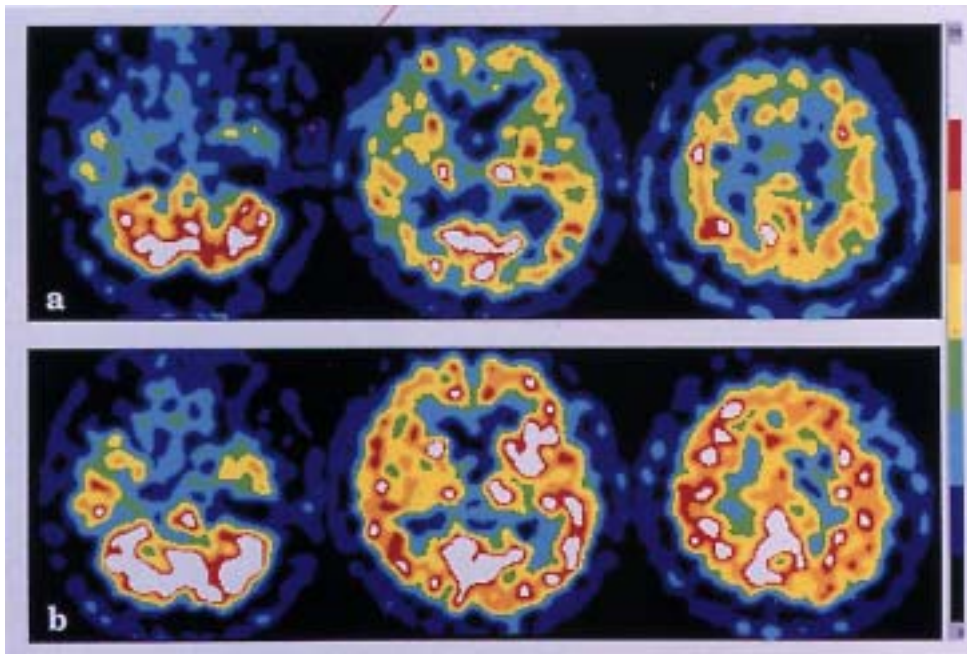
Quantitative single-photon emission computed tomography (SPECT) images at the level of the cerebellum (left), basal ganglia (middle), and lateral ventricle (right). a: SPECT immediately after initiation of therapy reveals generally low blood flow in the cerebrum and the cerebellum (April 1998). b: Six months after initiation of therapy, blood flow shows significant improvement, which is especially marked in the cerebellum (October 1998).
